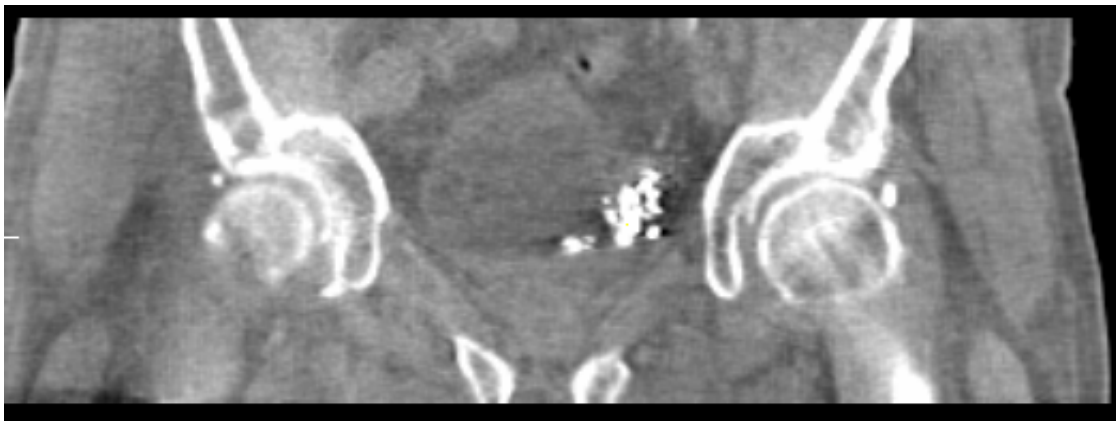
Coronal view of a CBCT image using created preset Bladder B.
